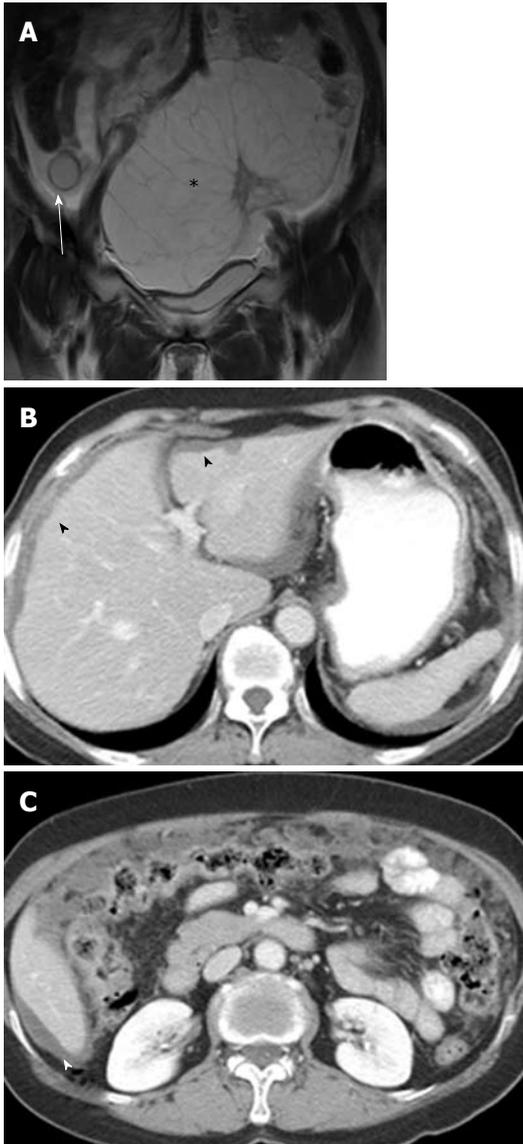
Coexistence of a mucinous cystadenoma of the appendix and ovary in a 63-year-old woman. A: Coronal T2-weighted MR image shows a well-defined cystic mass with hyperintensity in the appendix (arrow) and a multiloculated cystic mass in the left ovary (asterisk); B, C: Contrast-enhanced CT images show low-attenuation mucinous deposits in the peritoneal cavity and scalloping of the liver margin (arrowheads), suggestive of pseudomyxoma peritonei. CT: Computed tomography; MR: Magnetic resonance.
